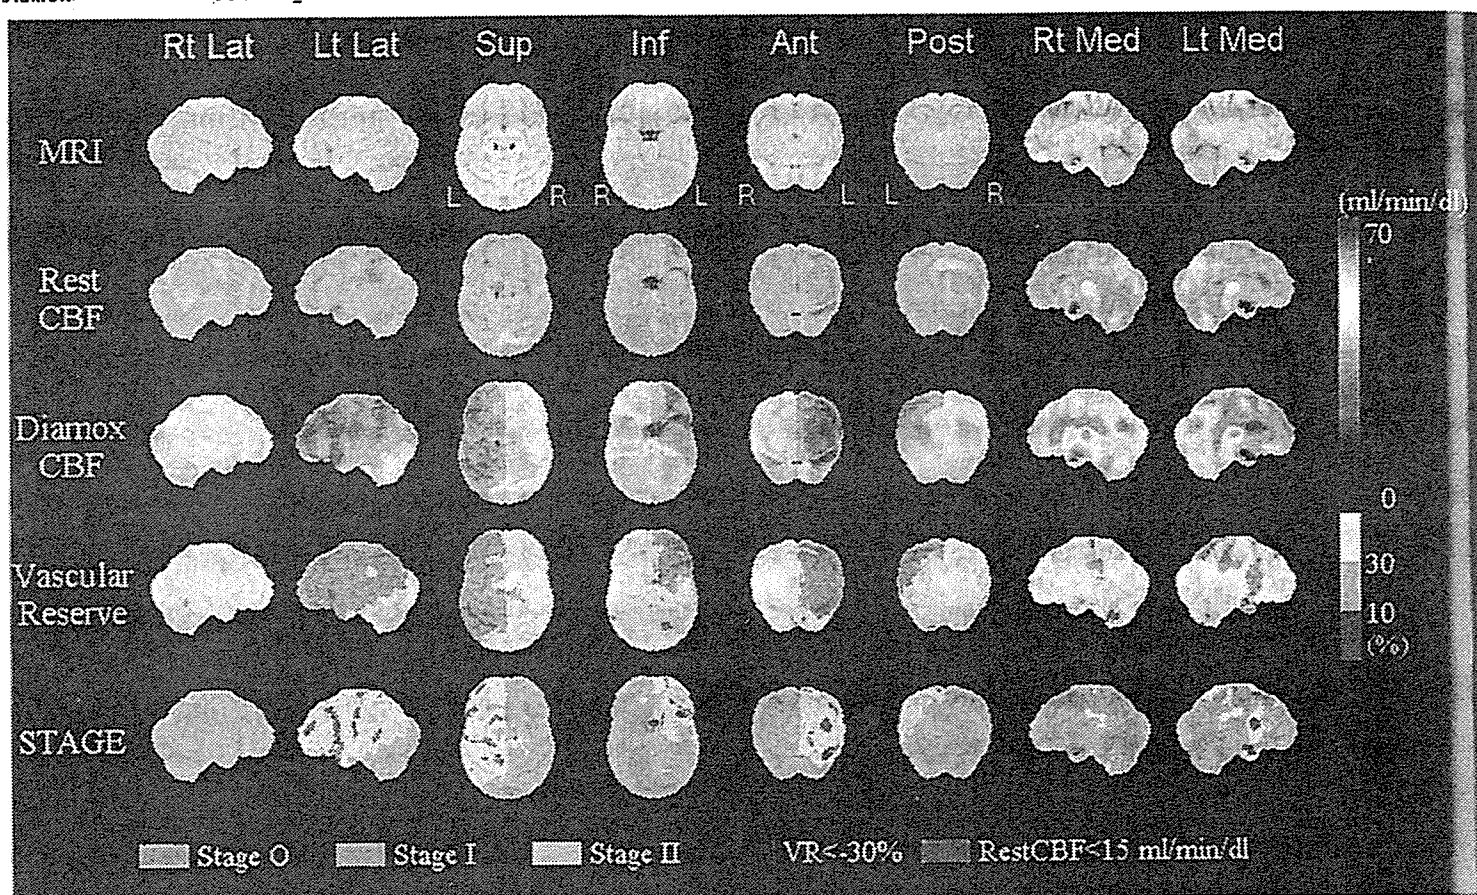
図 4-9 の症例での術前脳血流 SPECT の SEE 解析
